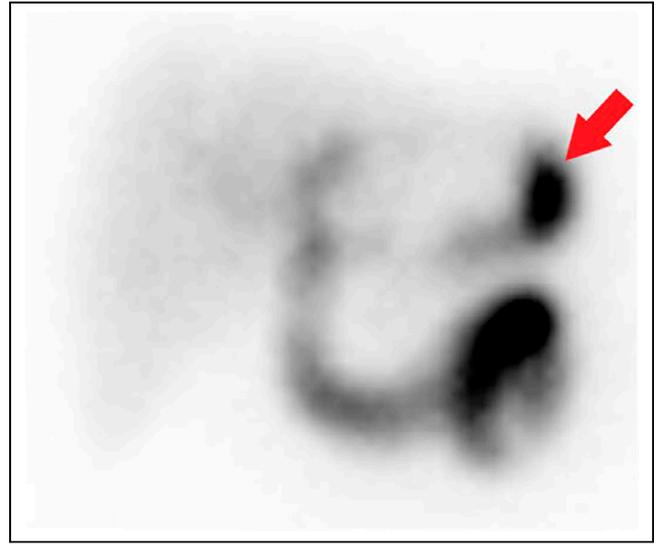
In this selected hepatobiliary scintigraphy image 40 min after injection of ^{99m}Tc -mebrofenin, there is moderate reflux (arrow) of radiopharmaceutical in retrograde fashion to stomach. Enterogastric reflux can be cause of abdominal symptoms in patients and should be reported if seen.
